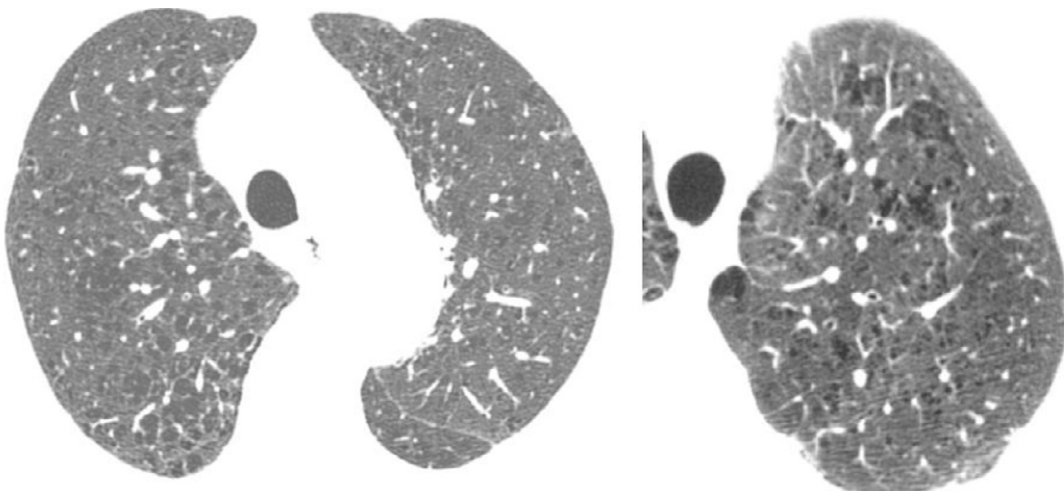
Axial CT scans with lung window settings revealing centrilobular emphysema in the upper lobes in a smoker.
